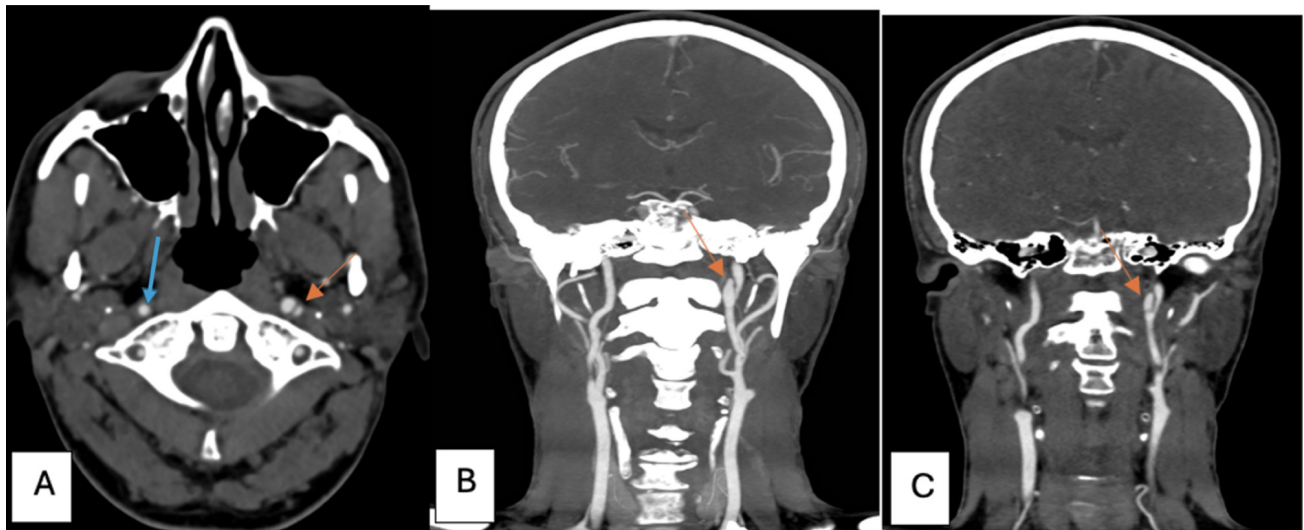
CT angiogram at 6 months showing the resolution of the right internal carotid artery (ICA) and the pseudoaneurysm of the left ICA. (A) Axial CT angiogram showing the resolution of the right ICA (blue arrow) and the 5 mm pseudoaneurysm of the left ICA (orange arrow). (B,C) Coronal CT angiograms showing the 5 mm pseudoaneurysm of the left ICA (orange arrows).
